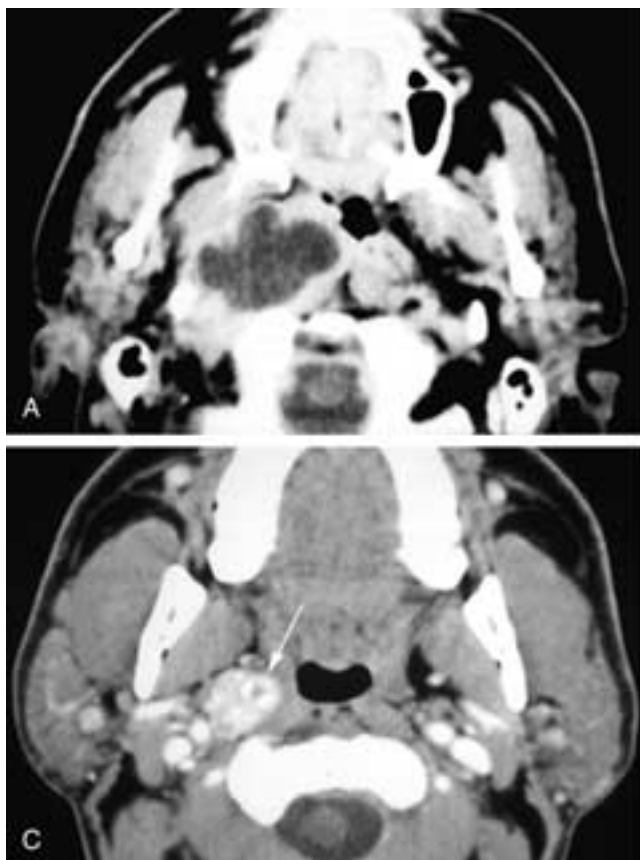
Axial contrast-enhanced CT scan (A) shows a slightly lobulated cystic mass in the right parapharyngeal space. The walls of the lesion are irregular and thick, and there is effacement of the adjacent fat planes. This was a metastatic squamous cell carcinoma within a lymph node. The primary tumor was more caudal in the oropharynx. Almost always when there is a necrotic retropharyngeal node, either the primary tumor is known or there are other metastases to lymph nodes. Axial contrast-enhanced CT scan (B) shows a thin-walled cystic mass in the right parapharyngeal space. There is minimal nodularity along the cyst wall, which differentiates it from a branchial cyst. This was a metastatic squamous cell carcinoma from a palatine tonsil tumor. Axial contrast-enhanced CT scan (C) shows an enhancing mass (*arrow*) adjacent to the right parapharyngeal space, immediately anteromedial to the carotid sheath. This is the location of most retropharyngeal lymph nodes. This was a metastatic papillary thyroid carcinoma node.
